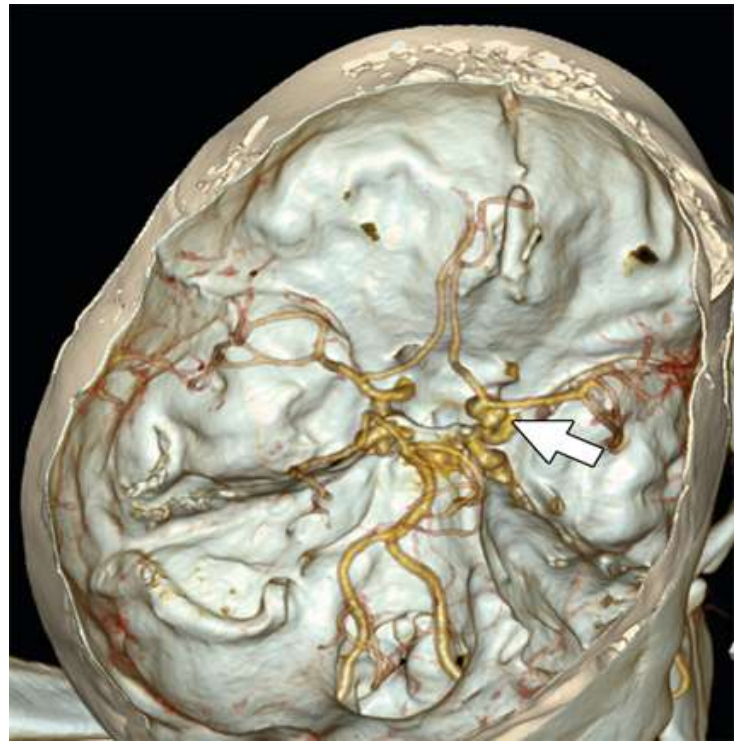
Shows a 60-year-old woman with a headache having a CT angiography of her Willis circle. volume-rendered model of the head and intracranial arteries using a clip plane reveals a right posterior communicating artery paraclinoid aneurysm (arrow).
